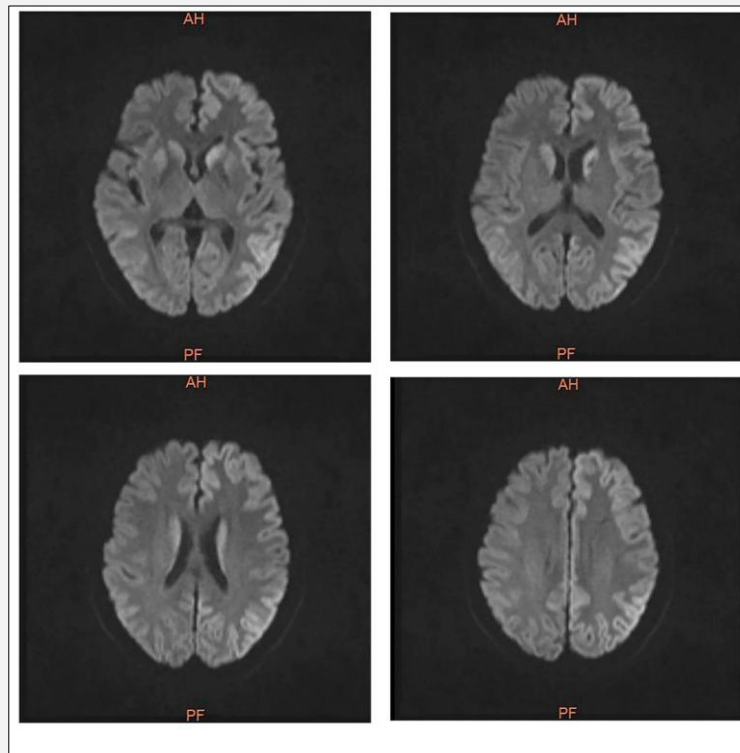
MRI of the patient's head after admission.
